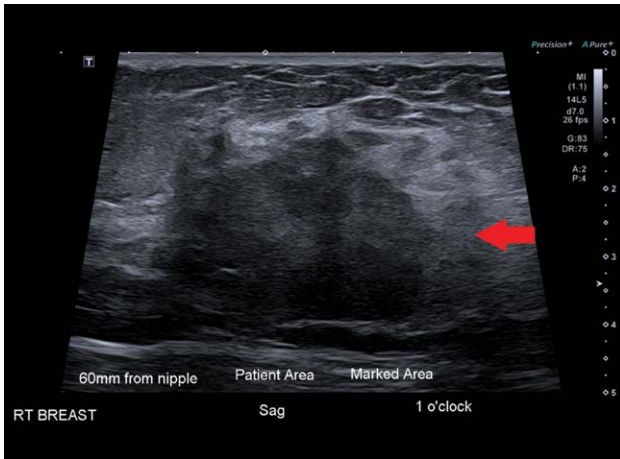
Ultrasound of the right breast at 12.00–1.00 o'clock, 60 mm from the nipple, showing a large hypoechoic lesion.
